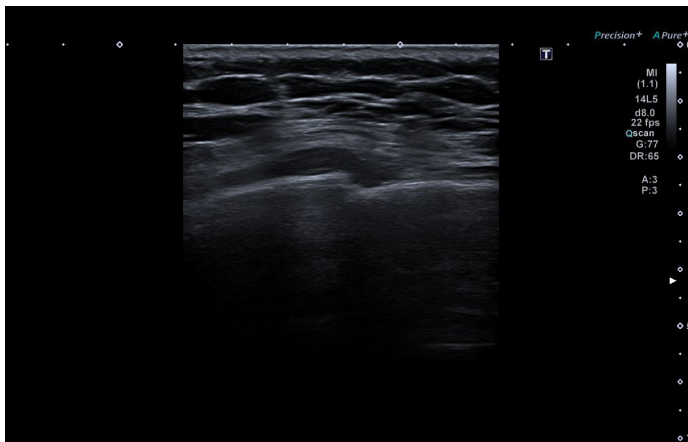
Cortical discontinuity and stepping sign in the ultrasonographic examination of right 10th rib with linear probe
